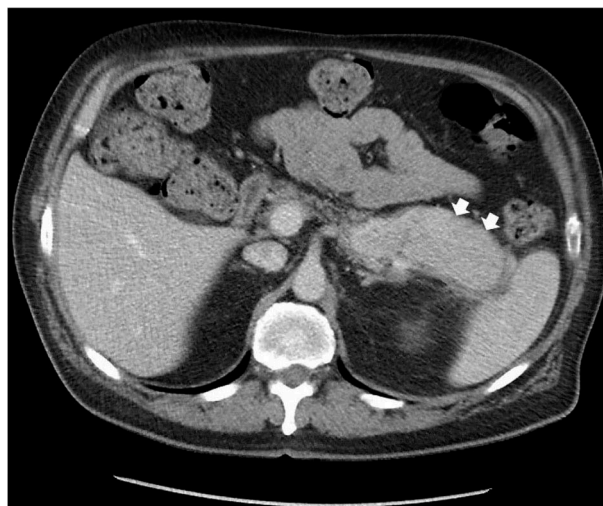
A CT scan with contrast of abdomen showed a large, heterogeneously enhancing mid to distal pancreatic mass measuring 9.4×3.8 cm with surrounding low-attenuation soft tissue thickening (white arrows).
